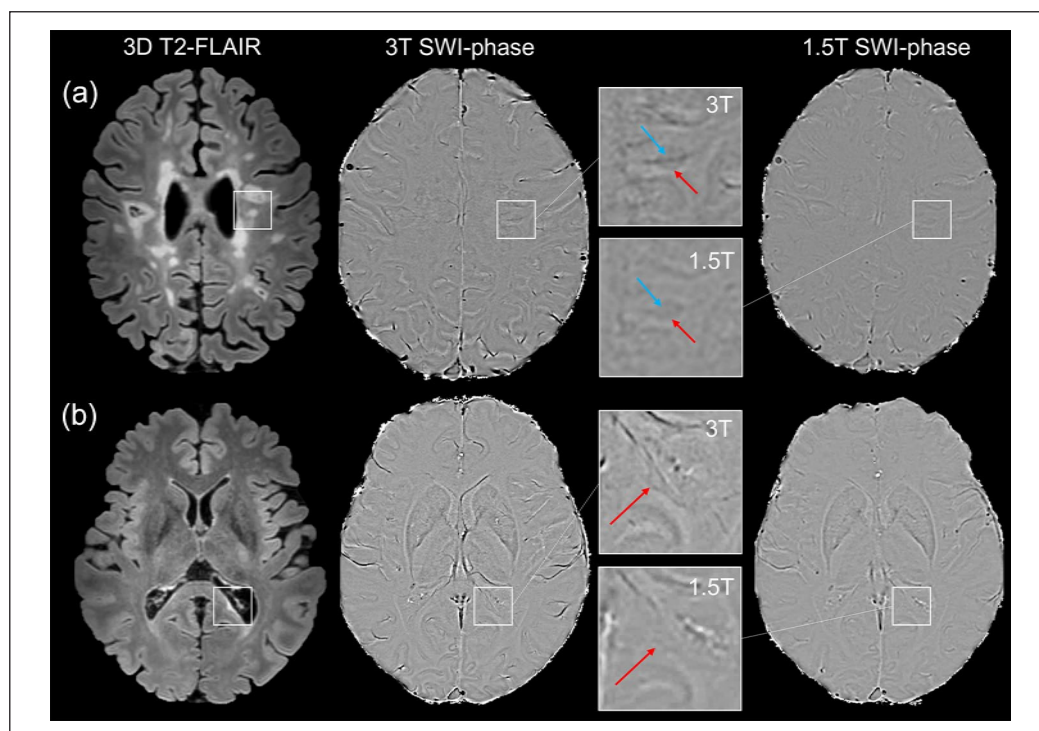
Discordant PRL at 1.5T versus 3T MRI. (a) Axial 3D FLAIR and SWI phase images from subject #11 (Table 1) showing a small white matter lesion (red arrow) classified as PRL at 3T MRI, but as hypointense nodular at 1.5T MRI. The time lapse between scans was 2.5 years. The central vein (blue arrow) is also more visible at 3T. (b) Axial 3D FLAIR and SWI phase images from subject #5 (Table 1). The occipital horn of the lateral ventricle, periventricular draining venules, and the optic radiation make difficult the PRL detection at 1.5T. The time lapse between scans was 0.1 year. For both cases, PRL magnification is shown in the insets at both 1.5 and 3T MRI.
